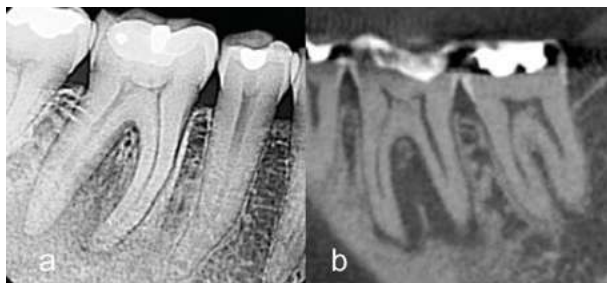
A patient was referred for evaluation and treatment of tooth #30. Patient presented with pain to percussion and no response to cold testing. Periodontal probing depths were all less than 3mm. Root canal treatment was indicated based on 2-D radiographic findings and clinical tests. 1A is a periapical radiograph of tooth #30. 1B is a CBCT sagittal view of tooth #30. A periapical low-density area involving both mesial and distal roots as well as the furcation was detected.
